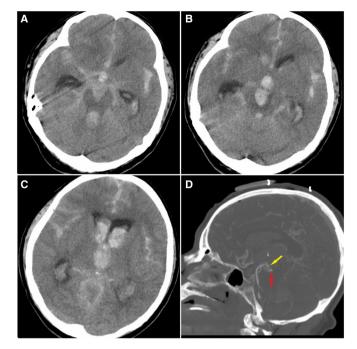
(A) Non-enhanced CT scan revealing severe acute cisternal subarachnoid haemorrhage, especially in the interhemispheric and sylvian compartments, as well as acute brainstem intraparenchymal haemorrhage. (B,C) More rostral slices of the same CT scan demonstrating intraventricular haemorrhage in the third ventricle and frontal horn of the lateral ventricles. (D) CT angiography demonstrating an abnormal vascular network at the tip of the basilar artery and possibly a small aneurysm.
